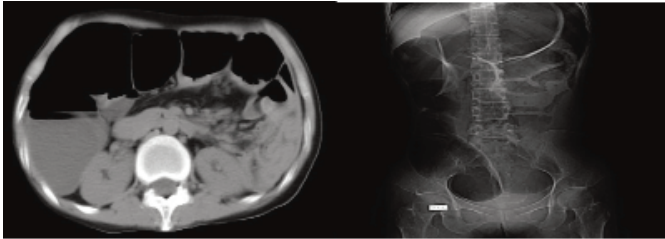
Computed tomography scan showed severe dilatation and pneumatosis of colon at the time of admission.
